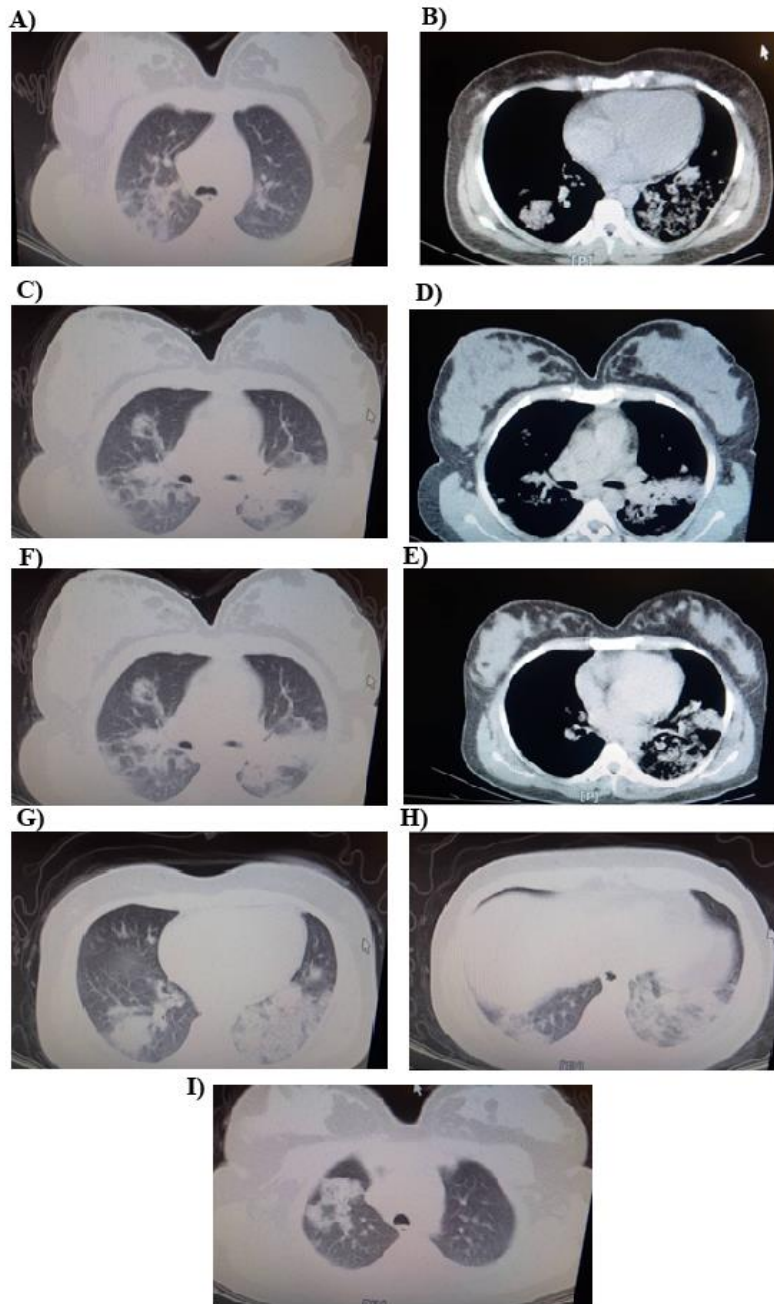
Serial images of the Chest CT scanning (A to I).
